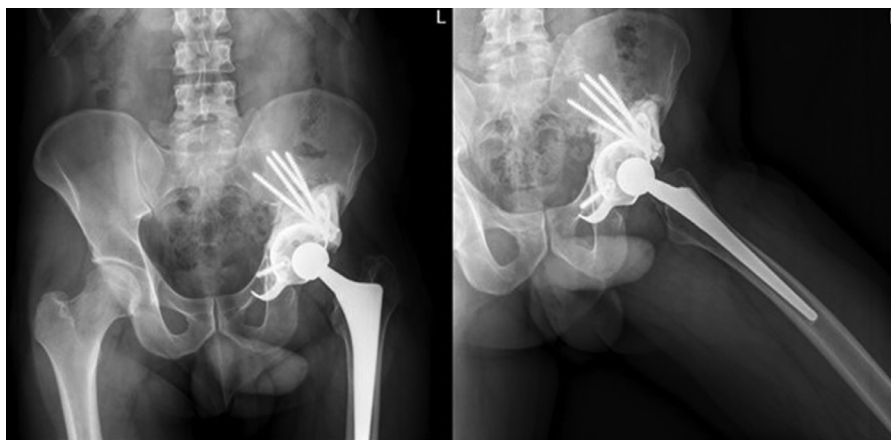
X-rays after cyst exeresis with implantation of left total hip prosthesis.
